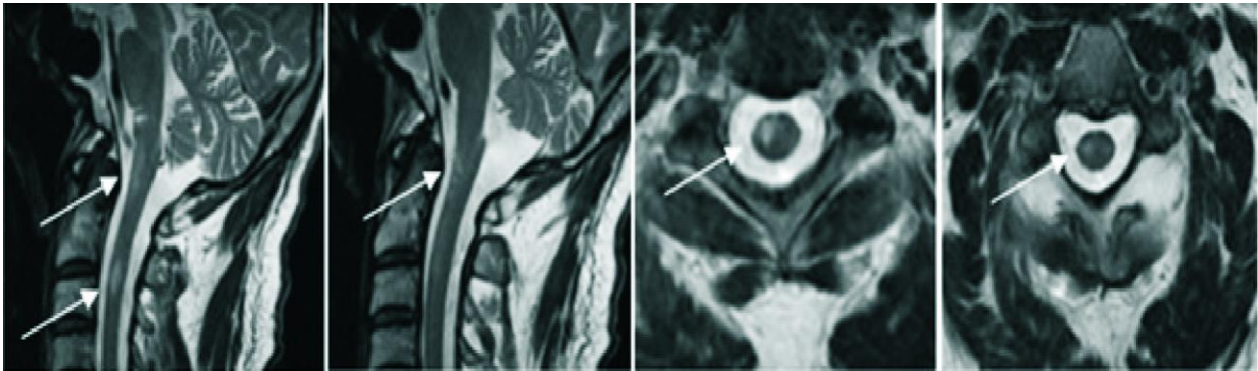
Cerebral and cervical MR imaging studies showed ischemic changes at right inferior portion of the medulla oblongata, at the level of craniocervical junction and at C2-C3 vertebra.
